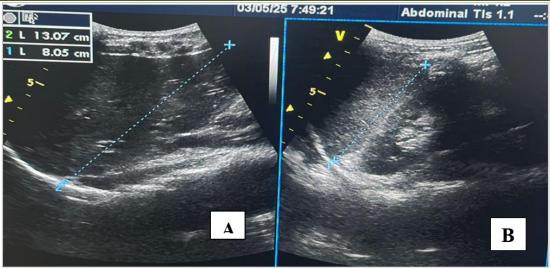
(A et B): Abdominal ultrasound showing a normal left kidney and an absent right kidney
